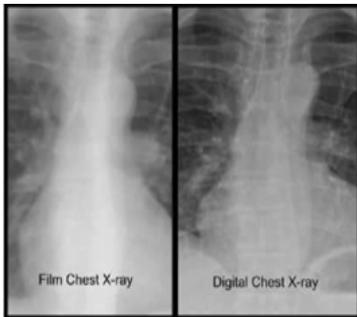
Analogue radiography (left), digital radiography (right).
